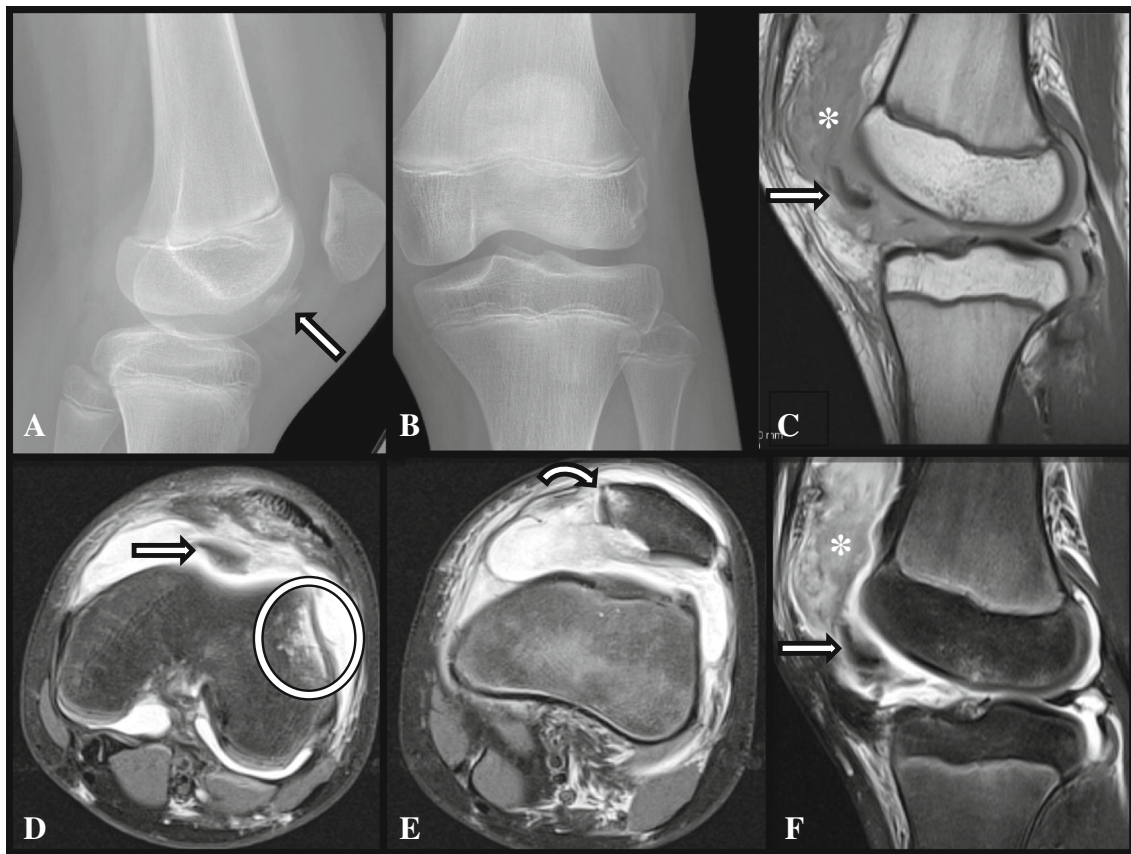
Patellar dislocation (relocated) (15-year-old patient with recent acute patellar dislocation). a AP and b lateral radiographs show a large displaced bony fragment anterior to the trochlea (*arrow*). d, e Axial fat-suppressed PD, f sagittal fat-suppressed PD, and c sagittal T1-weighted images confirm the large, displaced, and rotated osteochondral body
